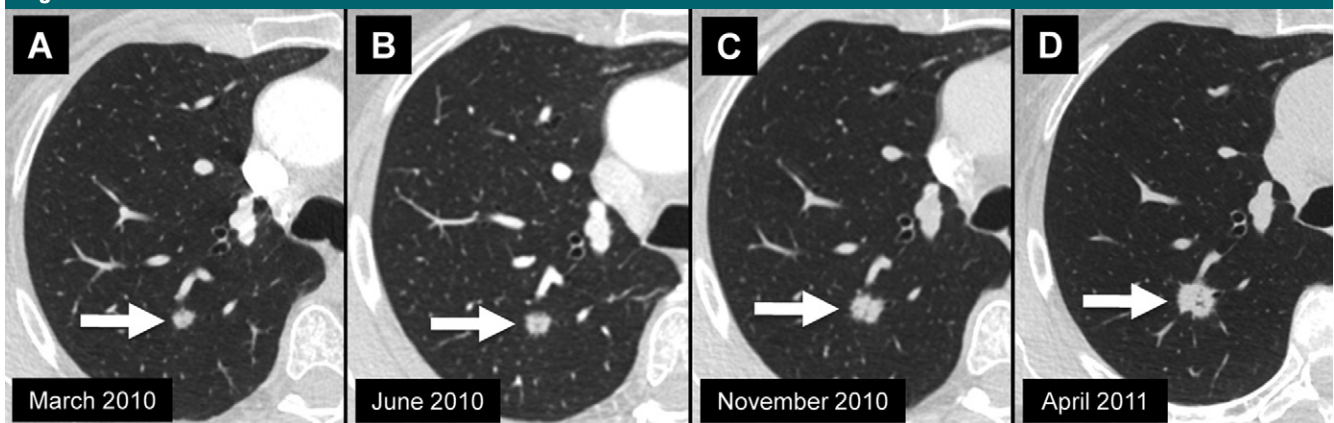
Sequential transverse CT sections through a solid nodule (arrow) in the right upper lobe. Average diameters of the nodule were, *A*, 8, *B*, 9, *C*, 11, and, *D*, 13 mm. Nodule growth is most obvious when we compare the earliest image with the most recent image. Surgery confirmed adenocarcinoma.
